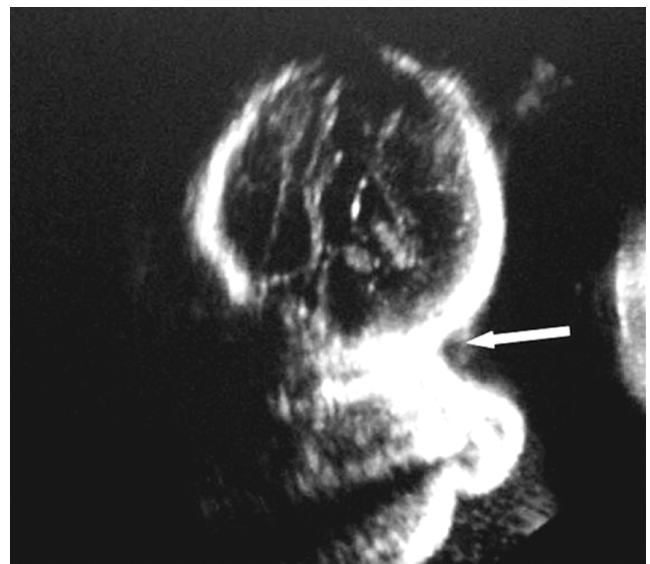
Ultrasonography reveals the short fetal neck with a hyperextended cervical spine (straight arrow) and upturned star-gazing face (curved arrow).
